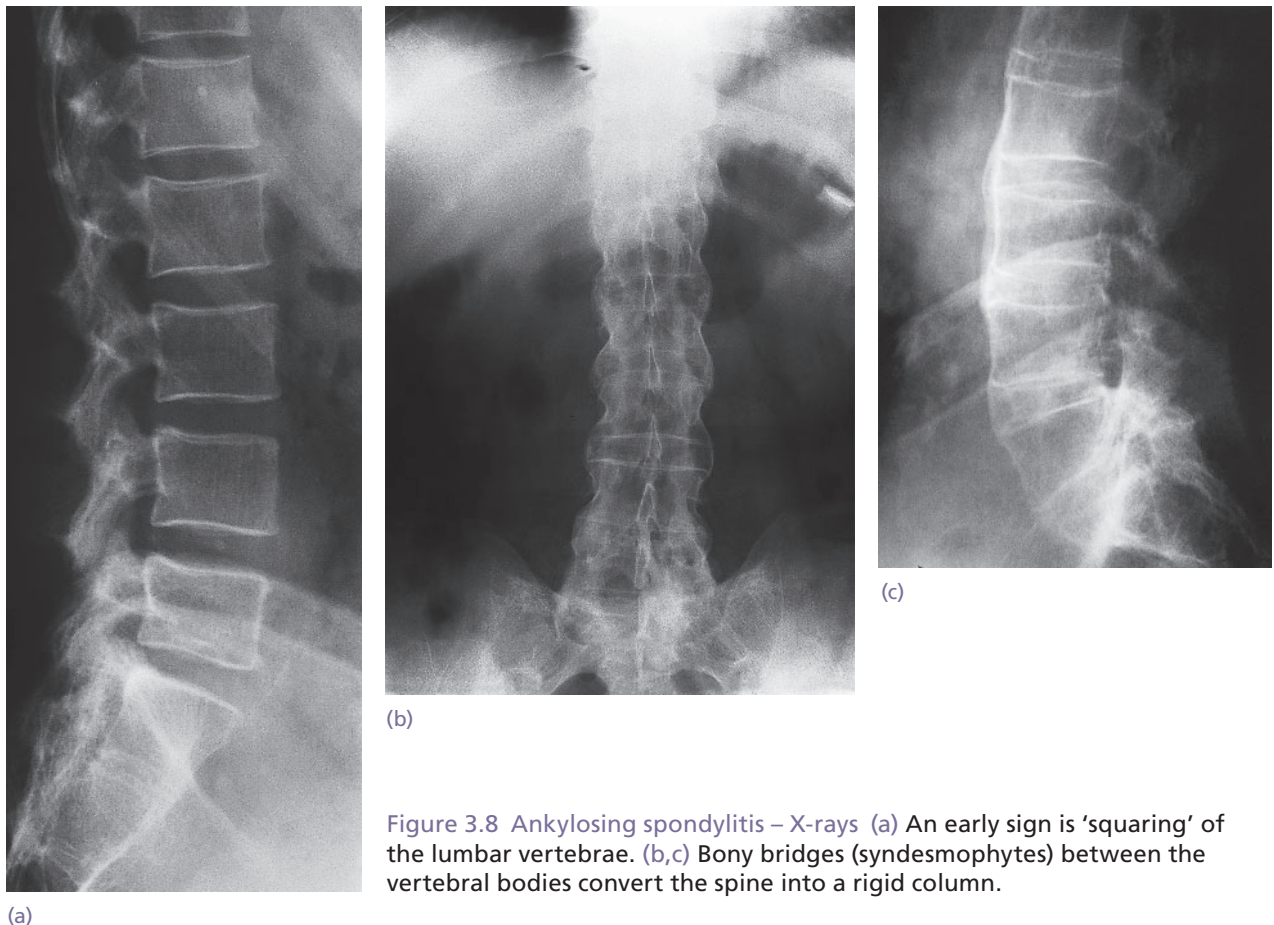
Ankylosing spondylitis – X-rays (a) An early sign is 'squaring' of the lumbar vertebrae. (b,c) Bony bridges (syndesmophytes) between the vertebral bodies convert the spine into a rigid column.
